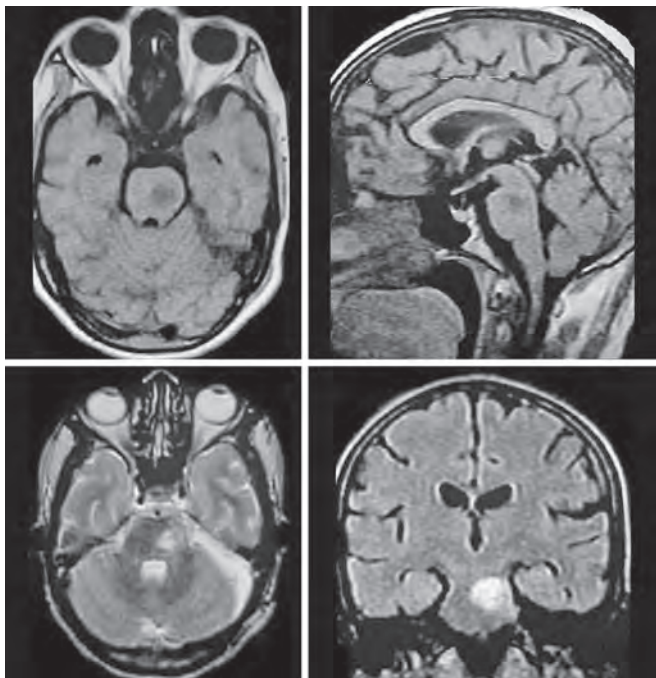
Post-operative MRI of the brain showing total excision of the brainstem hydatid cyst
